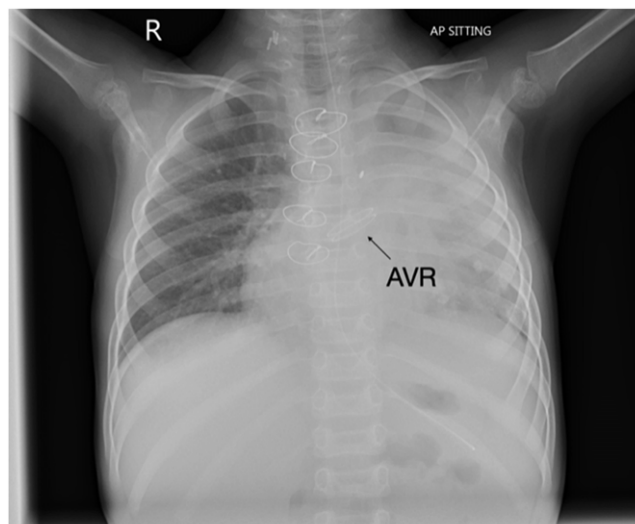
Chest radiograph demonstrating bileaflet On-X aortic valve.
